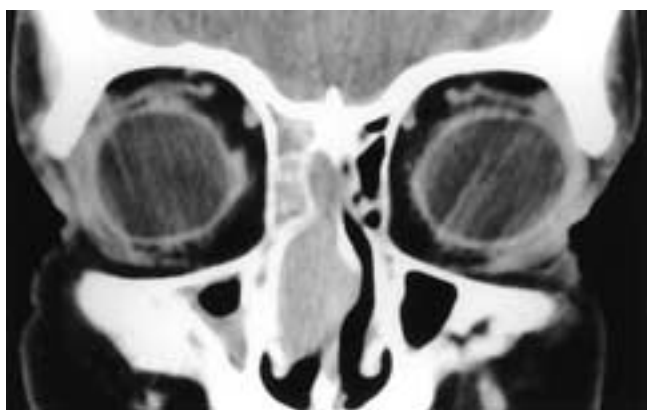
Coronal CT scan shows an expansile right nasal fossa mass obstructing the right ethmoid and maxillary sinuses. The lesion is limited to the sinonasal cavities. This patient had an olfactory neuroblastoma.
